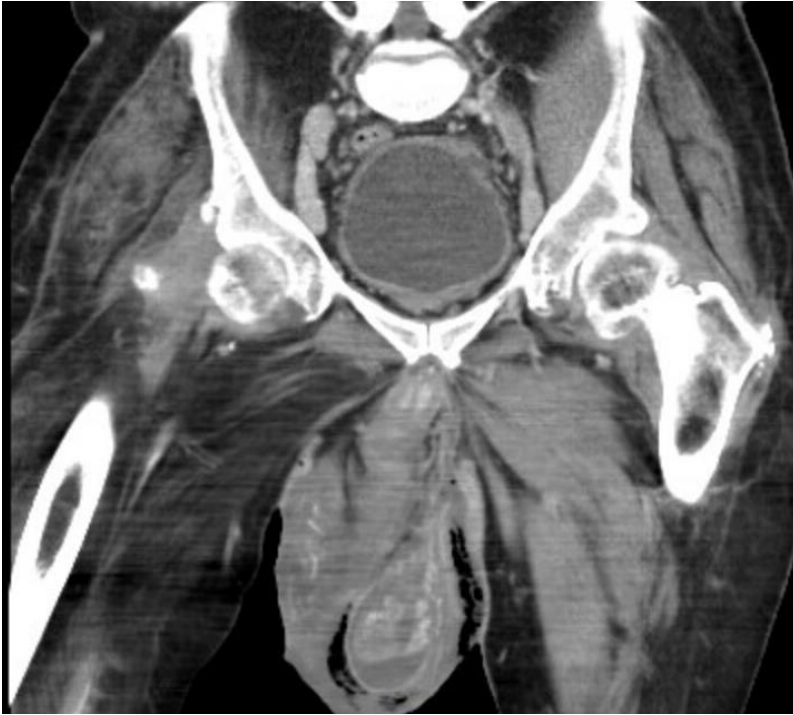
Fournier's gangrene noted on CT imaging
